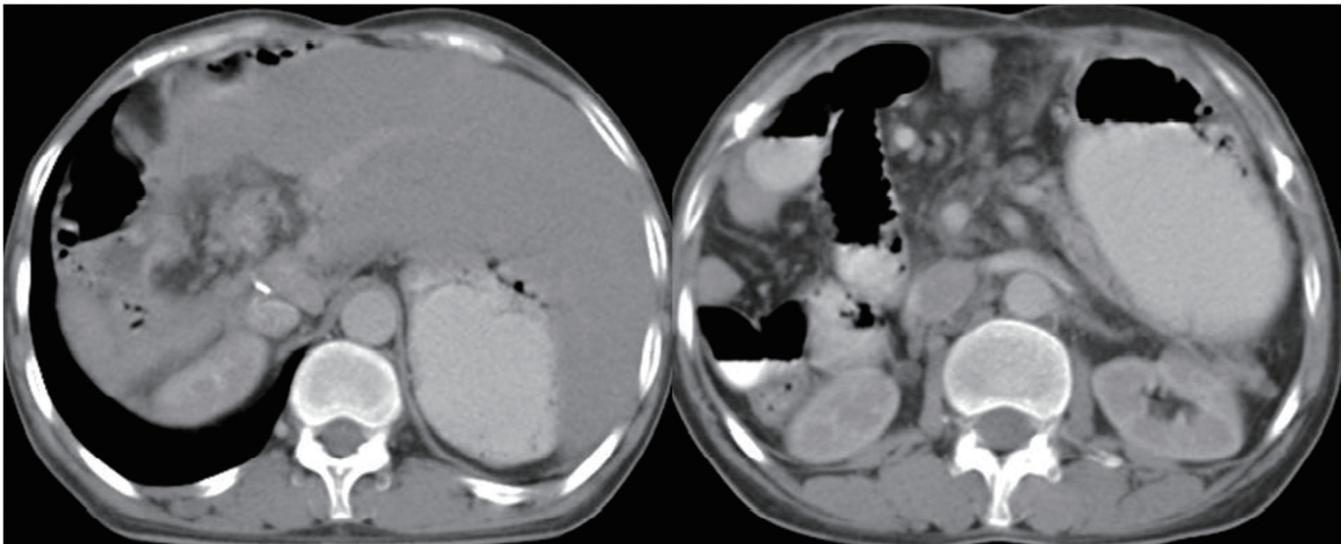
Contrast enhanced CT scan 2 years after right hepatectomy shows hypertrophy of the left lobe of liver and a small area of post-operative fibrosis with no evidence of recurrence of the tumor. Axial section at the level of pancreas also demonstrates no sign of recurrence with normal mesenteric fat
